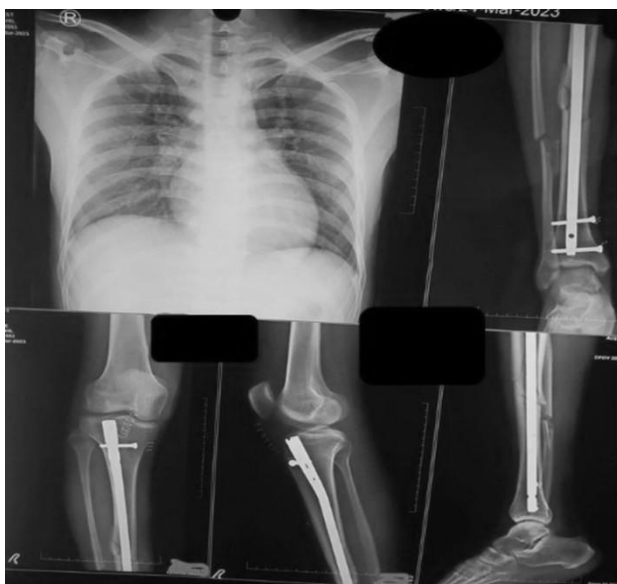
Radiograph obtained prior to discharge showing complete resolution of pulmonary infiltrates on chest X-ray, with a well-positioned intramedullary implant and satisfactory alignment of the tibial fracture.
